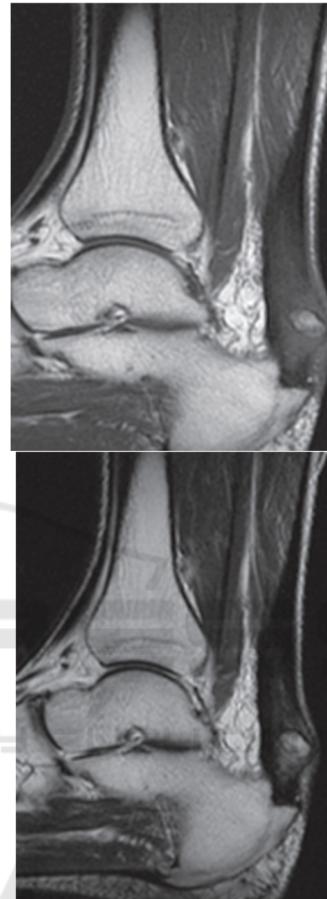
MRI manifestations of incomplete Achilles tendon tear.
